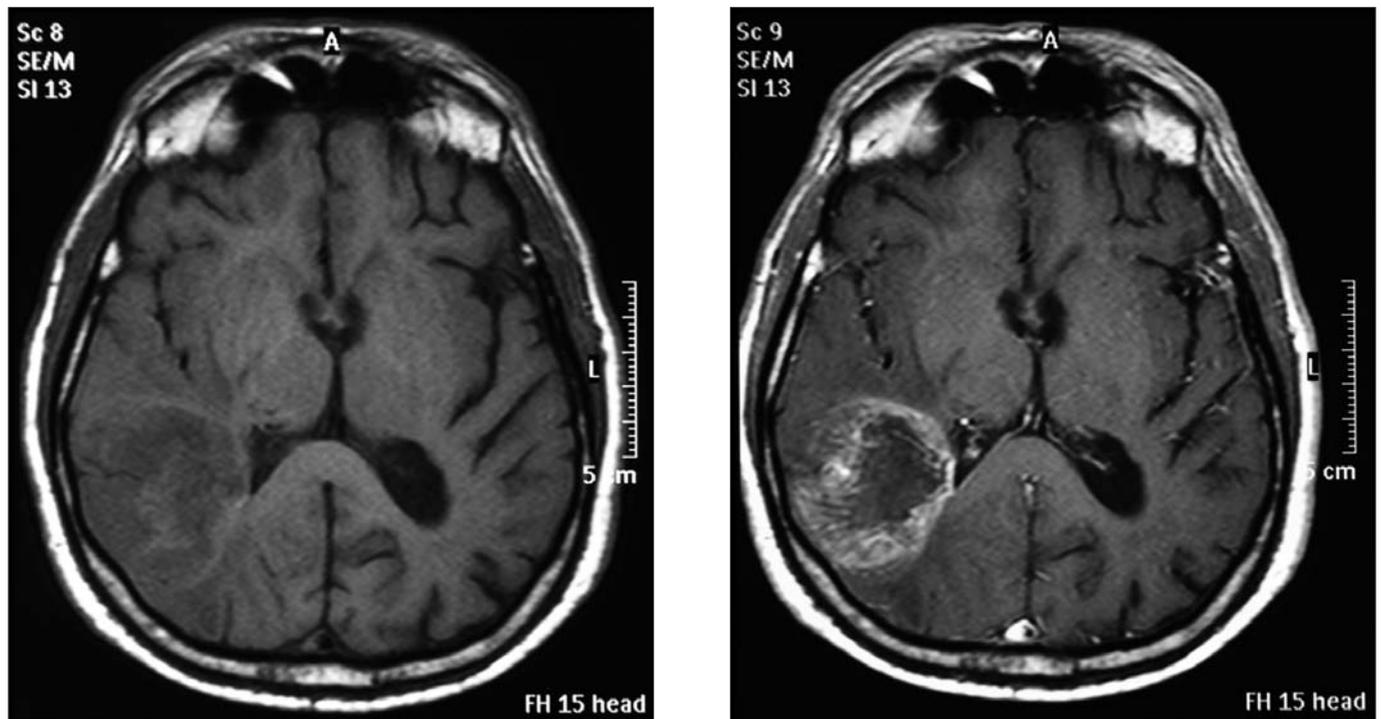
MRI of the brain with and without contrast.
